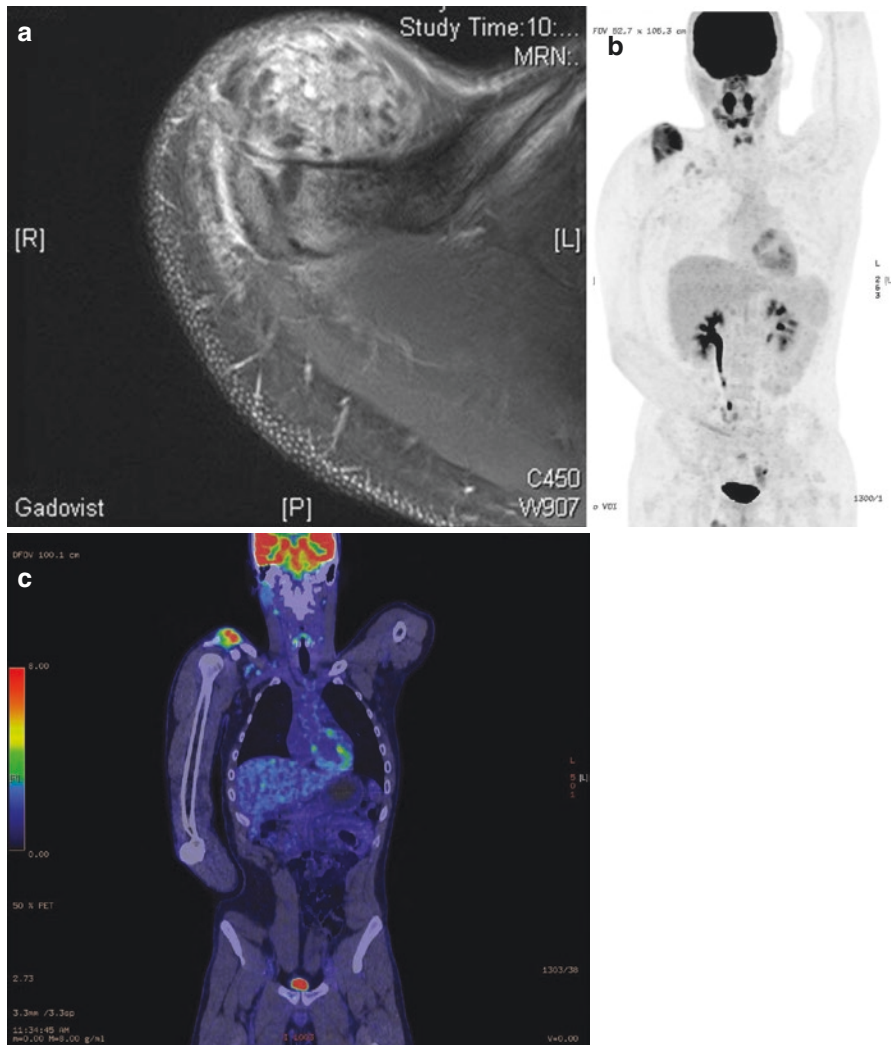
(a) A 21-year-old male presents with a painless right shoulder mass. Axial contrast-enhanced T1-weighted MRI image shows a heterogeneously enhancing soft tissue mass. (b) F18-FDG MIP image shows irregular but marked tracer uptake within the mass with further focal fainter uptake within the right axilla. (c) Coronal fused PET/CT image confirming uptake in the right shoulder lesion with further activity seen in multiple axillary lymph nodes. Percutaneous biopsy of the right shoulder and lymph nodes demonstrated malignant epithelioid tumour with lymph node metastases
